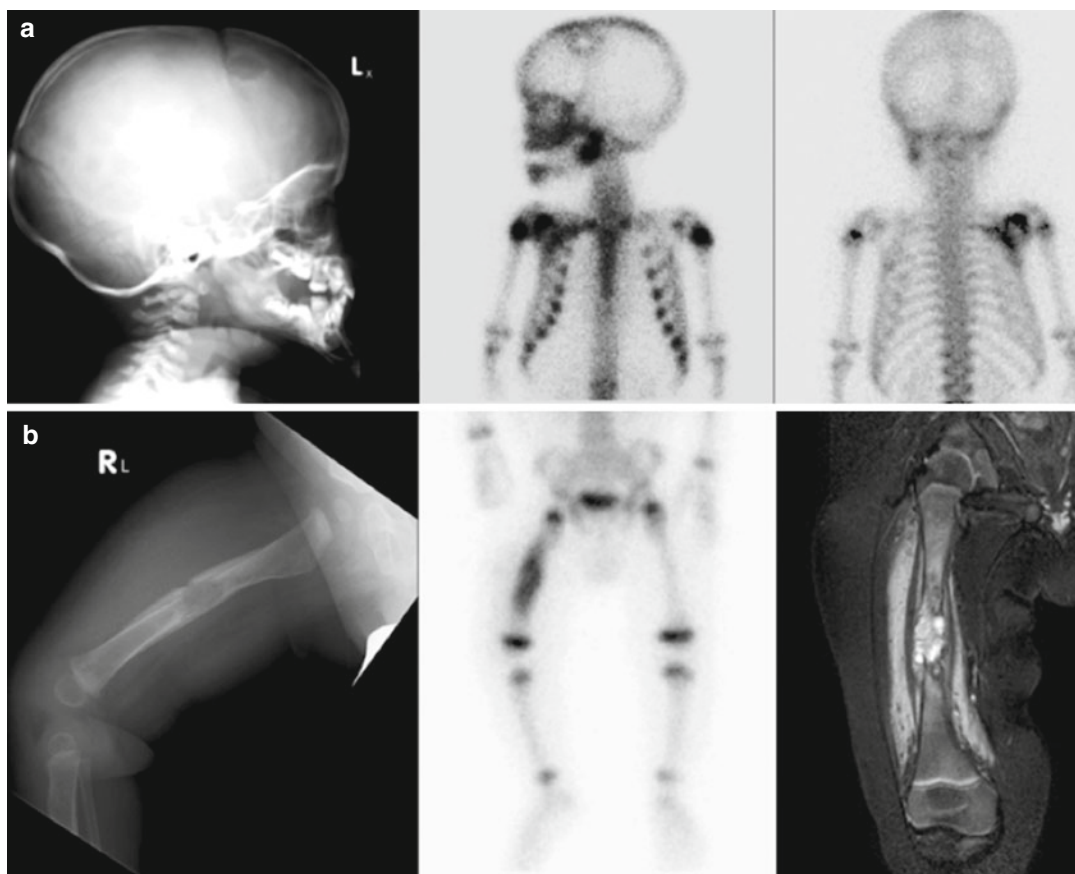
Langerhans cell histiocytosis. (a) A 7-year-old male presented with a mass on the left side of his skull. Biopsy confirmed LCH. Skull radiograph shows a typical geographic lytic lesion in the left frontal bone. On bone scintigraphy this is seen as a “doughnut” lesion with a peripheral rim of increased osteoblastic activity. The bone scan also showed other lesions in the left mandible, right scapula, and right second rib consistent with multiple sites of disease. (b) A 7-month-old male presented with decreased movement and pain in the right femur.
